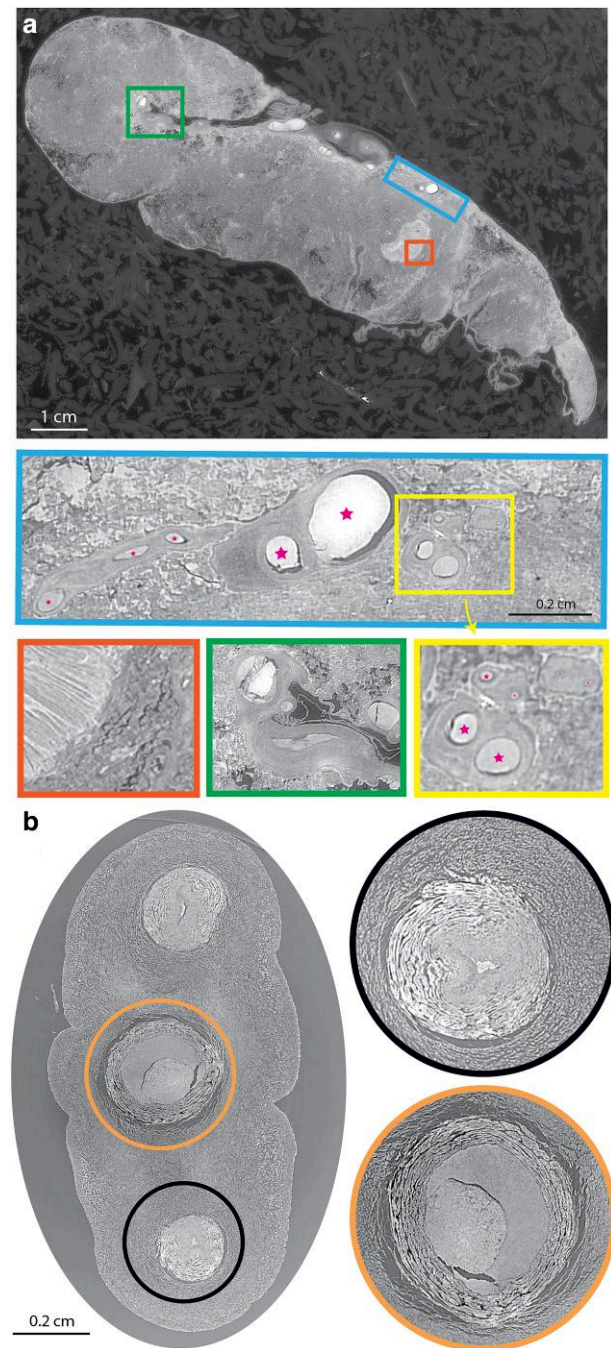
Physiological placenta recorded at the BM18 beamline using the HiP-CT protocol. a) Tomographic slice through the entire placenta (Table 1: BM18-T) with zoom-in at regions of interest (green, amniotic membrane; orange, infarctious regions; yellow, vasculature). Pink stars represent structures of the vascular network. b) High-resolution scan (Table 1: BM18-HR1) of umbilical cord with zoom-in at umbilical artery (black) and umbilical vein (orange).
